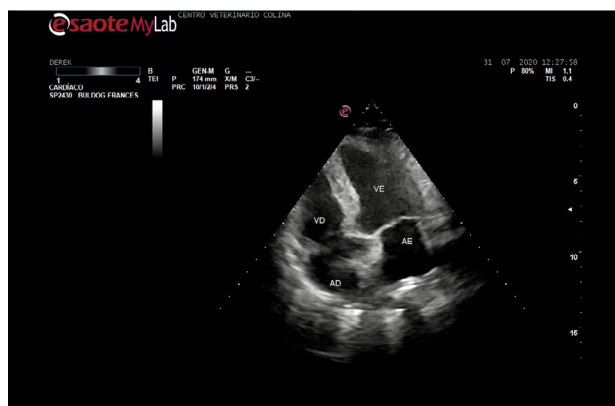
B-mode echocardiography, left apical four-chamber view, showing no morphological changes. VD=right ventricle; AD= right atrium; VE=left ventricle; AE=left atrium
